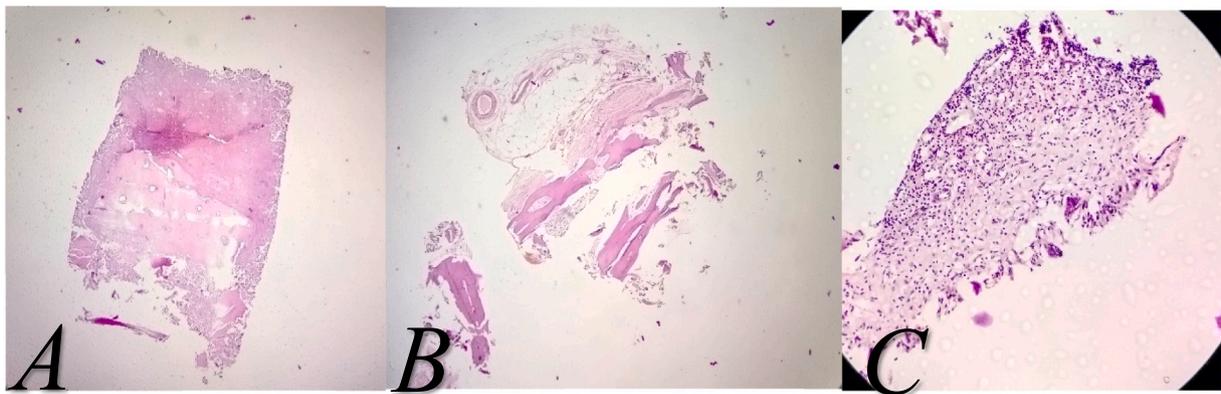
A, B: benign osseous and fibroadipose tissues. C: edematous fibrous tissue with mild inflammatory infiltrate and multinucleate giant cells. From the CT guided biopsy.
